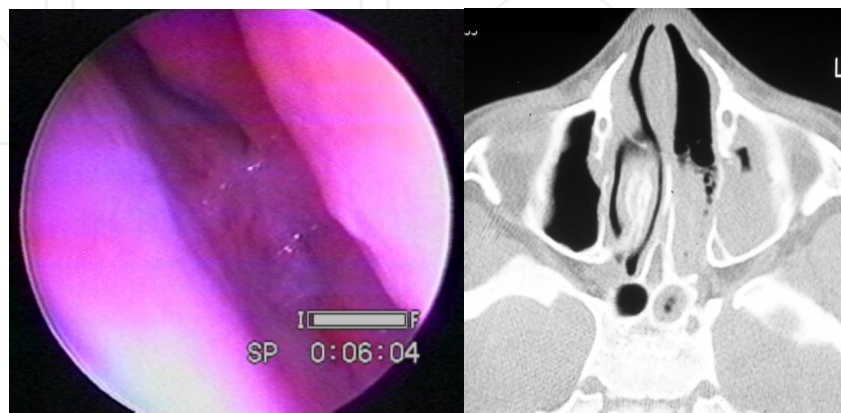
Choanal Atresia. (A) Endoscopic view: posterior nasal fossa, left side, with impermeable choana; (B) Axial CT scan, showing the choanal atresia at the left side.
